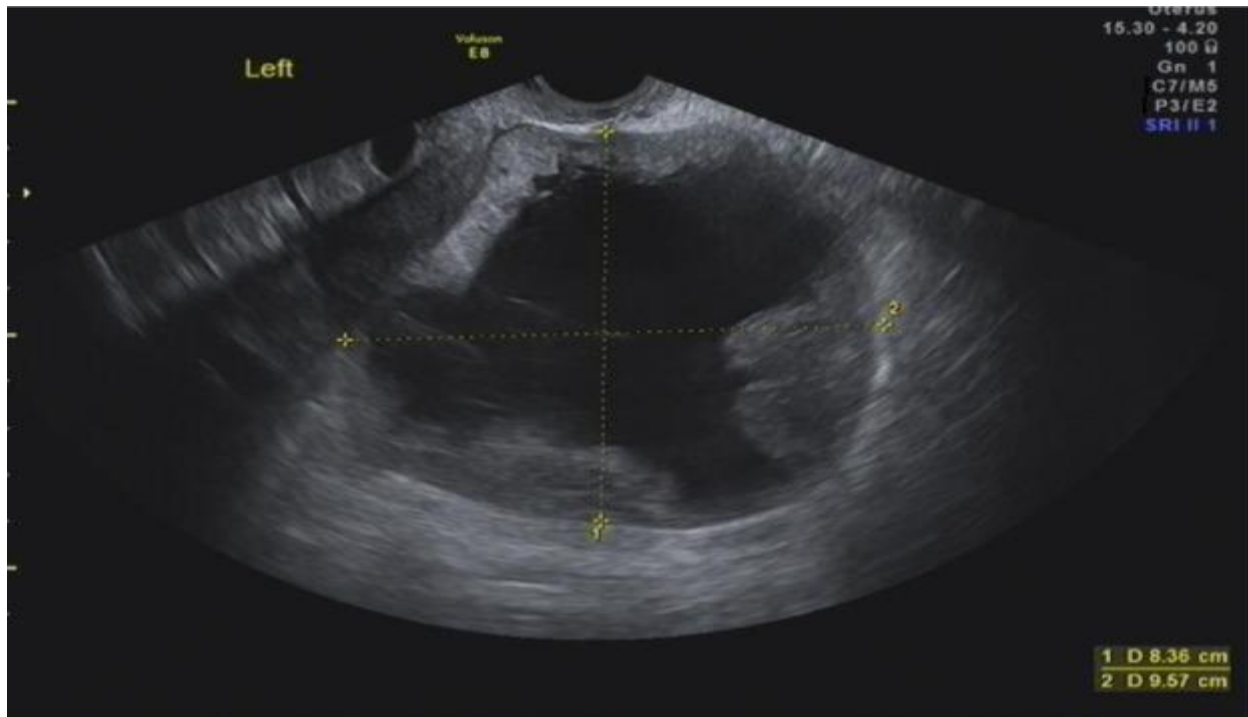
Transabdominal ultrasound scan in an 8-year-old girl with abdominal pain.
